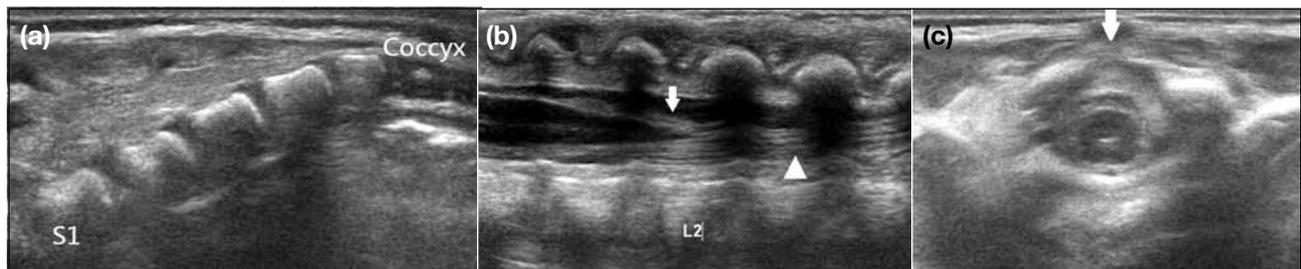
Normal neonatal lumbar ultrasonography: (a) a longitudinal image of the sacral region shows the normal S1-5 and coccygeal vertebrae. (b) A longitudinal image of the lumbar region shows the normal conus medullaris at the level of L2 (arrow) and the cauda equina (arrowhead). On real time imaging, motion of the cord and nerve roots with respiration should be seen. (c) A transverse image of the lumbar region shows the normal appearance of the conus medullaris and the intact posterior vertebral element (arrow).
